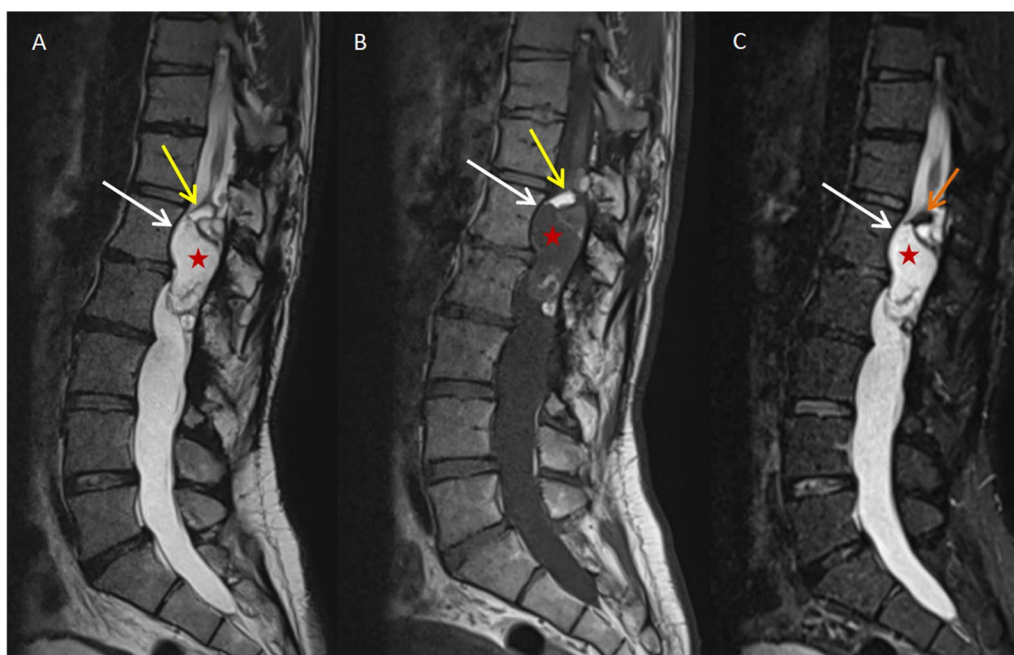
Sagittal MR images showing a mass within the cauda equina at the level of L1–L2. A Sagittal T2-weighted MRI sequence showing a mass (white arrow) within the cauda equina at the level of L1–L2, containing a cystic component (red star) and a fatty portion (yellow arrow), both displaying hyperintense signals. B Sagittal T1-weighted MRI sequence of the same mass (white arrow) within the cauda equina confirming the cystic nature (red star) as hypointense, with the fatty portion (yellow arrow) remaining hyperintense. C Short tau inversion recovery (STIR) sequence confirming the fatty nature of the upper component of the mass (orange arrow)
